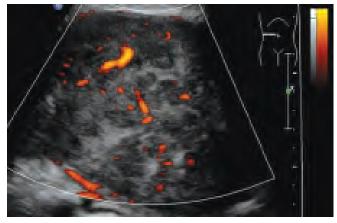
Uterine fibroid with secondary degenerative changes. Power Doppler ultrasound displays prominent color/ power signals within the central portion of the fibroid
